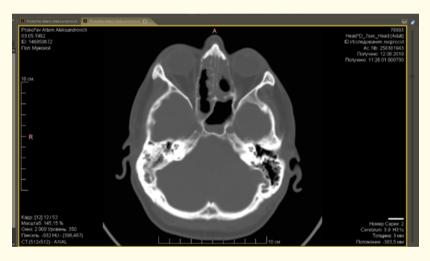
Computed tomography of the patient's brain from 08/12/2019.
